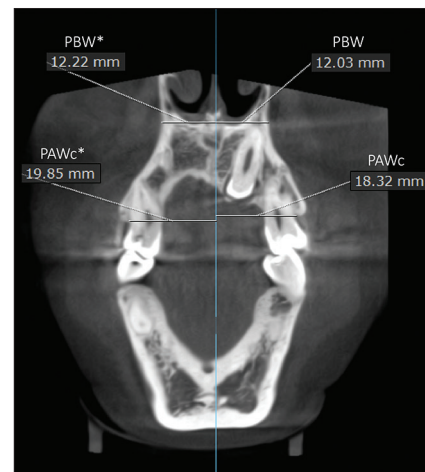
CBCT coronal section at the level of the maxillary first premolars. PBW: Maxillary first premolar basal width. PAWc: Maxillary first premolar alveolar width. * Indicating the non-impacted side. Vertical line = the midline, a perpendicular line from ANS
